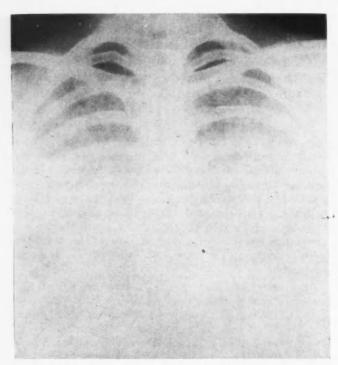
Admission radiograph, November 30, 1958. Dense non-homogeneous opacity, covering the lower two-thirds of both lung fields, is seen. No evidence of atelectasis or pleural fluid is present.
